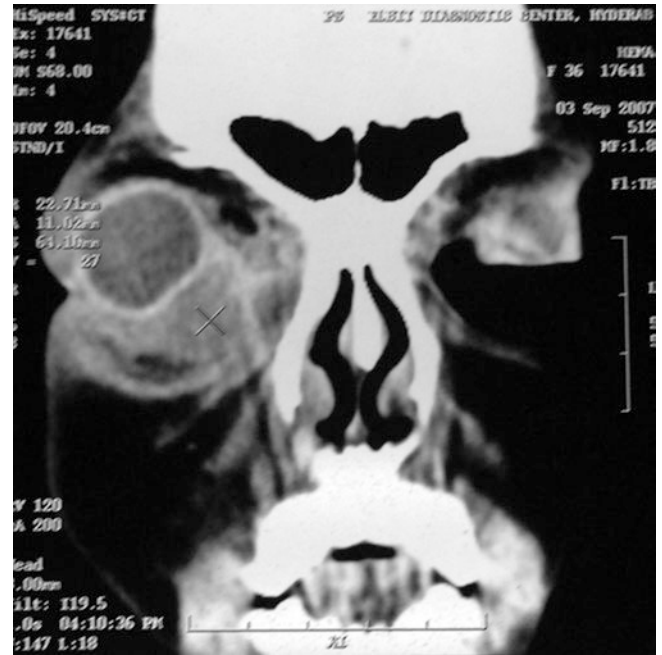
Coronal CT photograph of right orbital abscess associated with acute dacryocystitis
